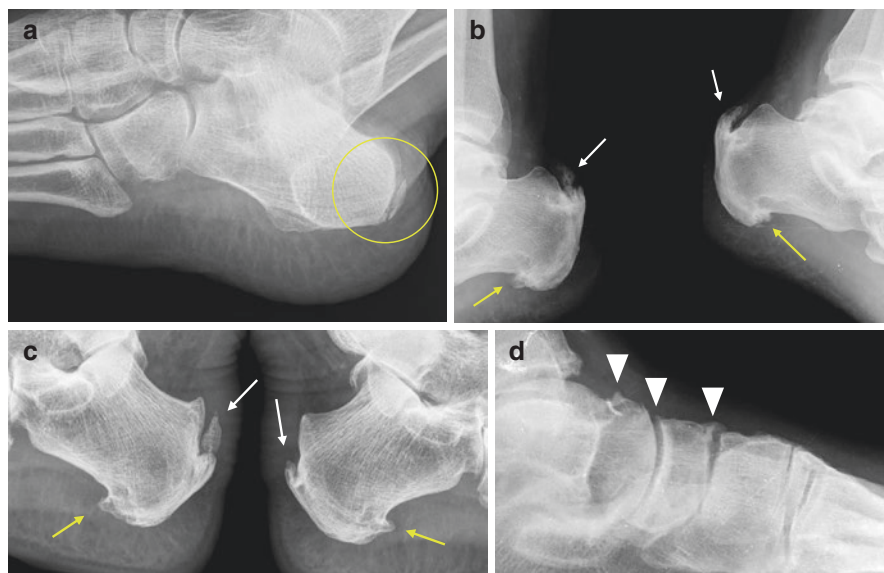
Radiographic findings – enthesophytes
